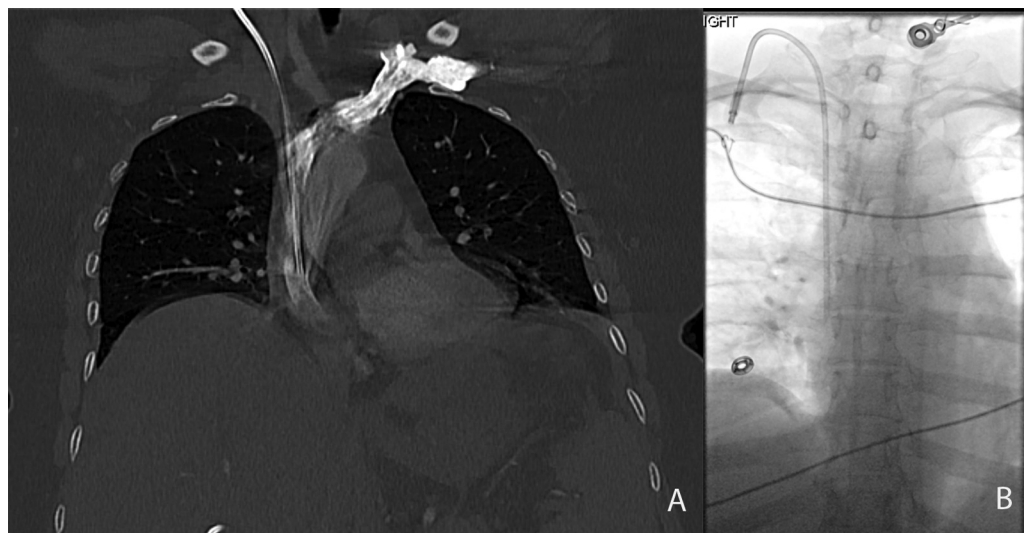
(A and B) Postprocedural computed tomography (CT) chest coronal and fluoroscopic image shows port tip in the lower superior vena cava (SVC).
